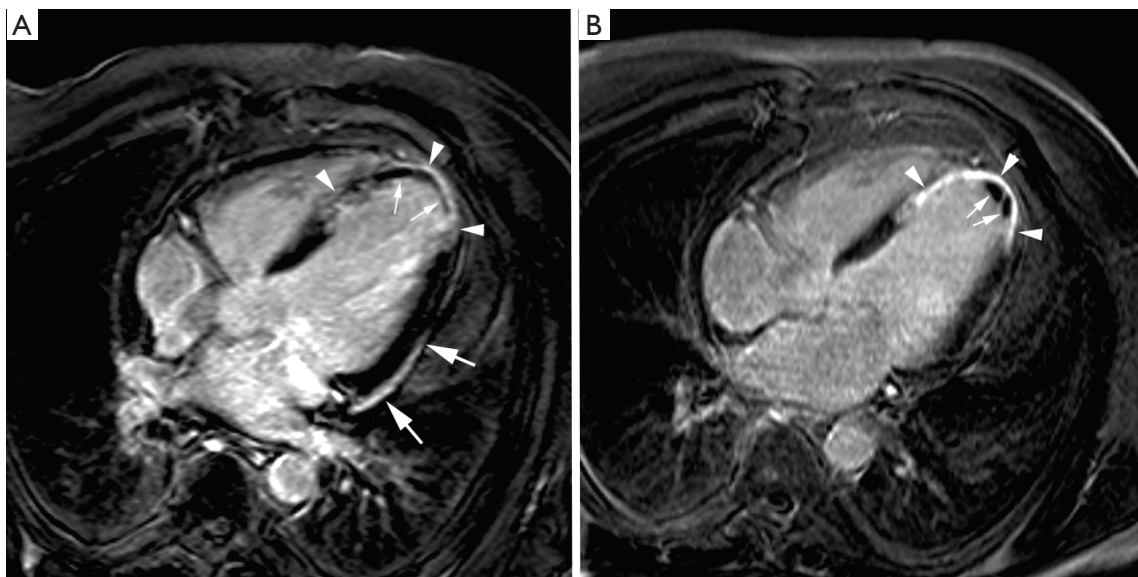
Evolution of an acute towards a healed myocardial infarction in a 52-year-old patient with anteroapical infarction. Late gadolinium imaging in horizontal image plane at 1 week (A) and 4 months (B) after the acute event. At 1 week, presence of diffuse enhancement of the apical part of the ventricular septum and LV apex (*arrowheads*, A) with large area of microvascular obstruction (*small arrows*, A). Note the presence of some pericardial enhancement over the laterobasal part of the LV (*arrows*, A). At 4 month follow-up, the infarct has thinned and strongly enhances (*arrowheads*, B). Note the presence of a small mural thrombus in LV apex (*arrows*, B). Adapted from *Ischemic Heart Disease* by Bogaert J and Dymarkowski S, in *Clinical Cardiac MRI Second Edition*, Bogaert J, Dymarkowski S, Taylor AM, Muthurangu V (eds). Springer Heidelberg, Germany (ISBN 978-3-642-23034-9)
